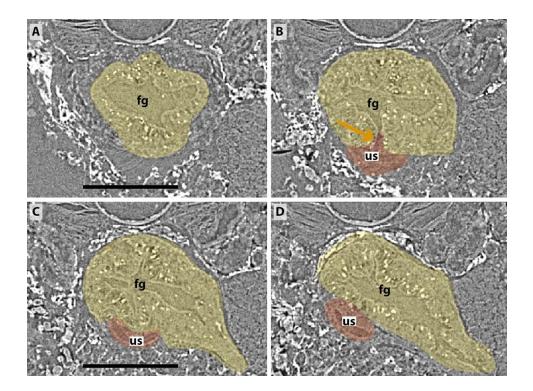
Sections of synchrotron X-ray microtomography of a juvenile of *Lepidosiren*
